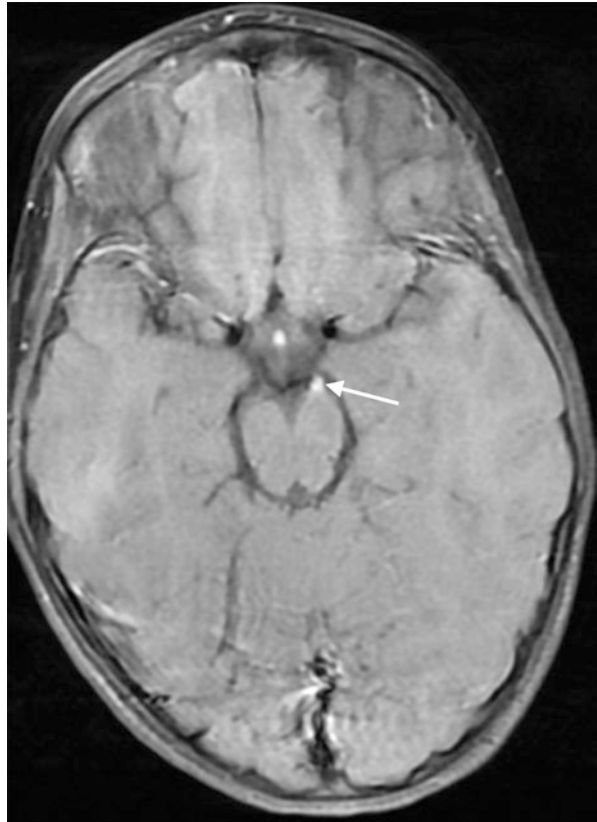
Axial T1 postgadolinium MRI shows the typical bright signal at the left third nerve (*arrow*) exit zone between the cerebral peduncles
